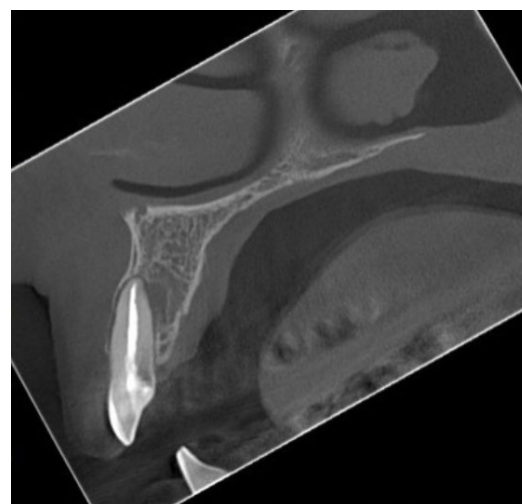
6-month follow-up CBCT image showing a periradicular lesion under repair
